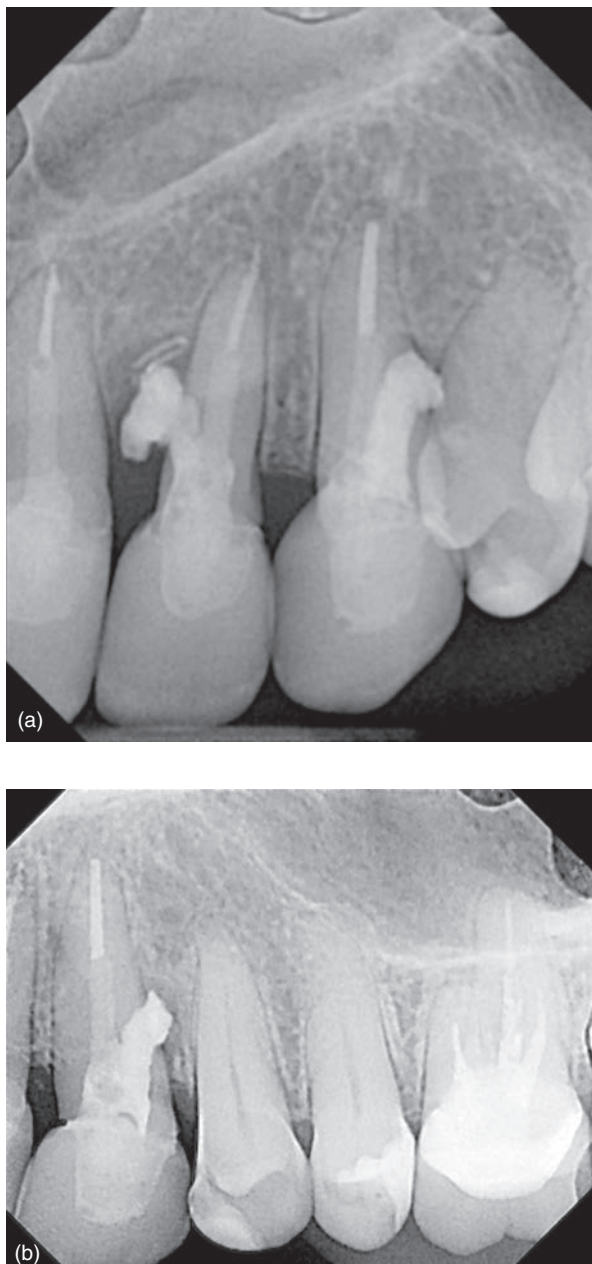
Radiographs of two separate cases of perforation repair with MTA showing defects in bone around the repair due to an inability to control the material.
